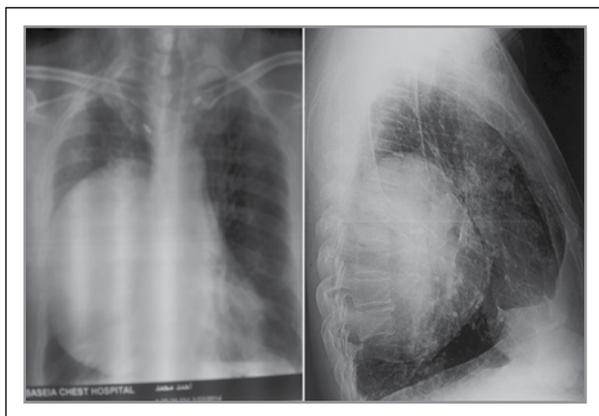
Round hyperdense shadow in right inferior region in Postero-anterior view and in posterior region in Lateral chest X-ray
